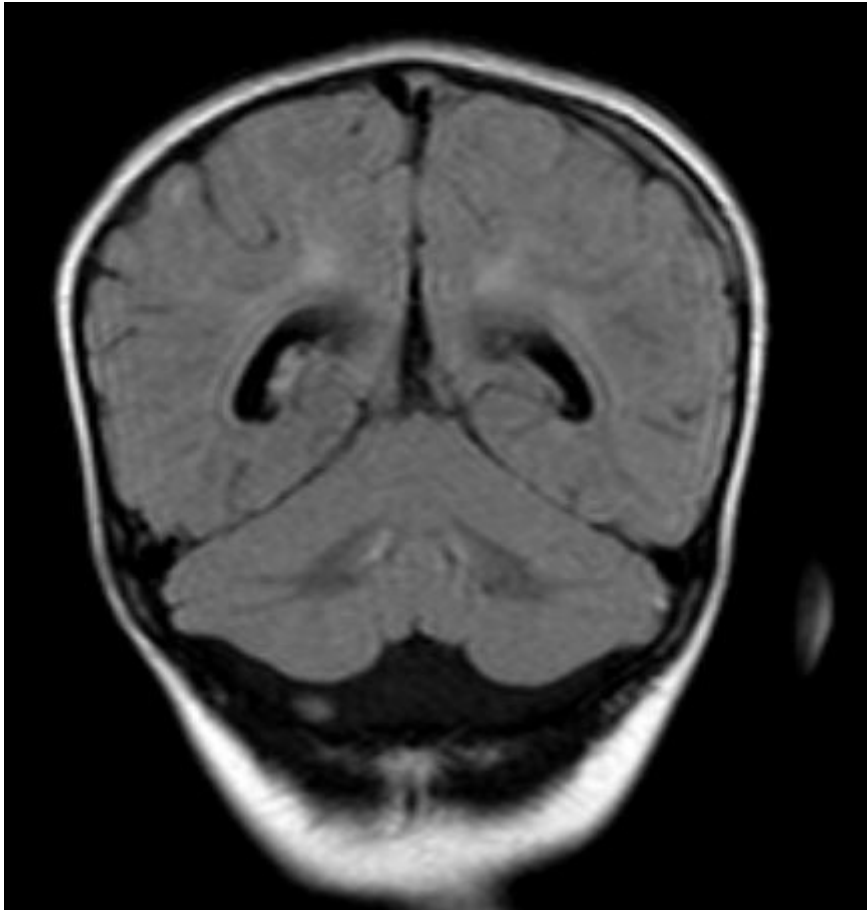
(C) MRI brain scan of III.6 at 2 years. The coronal image (C) does not show evidence of cerebellar abnormalities.
